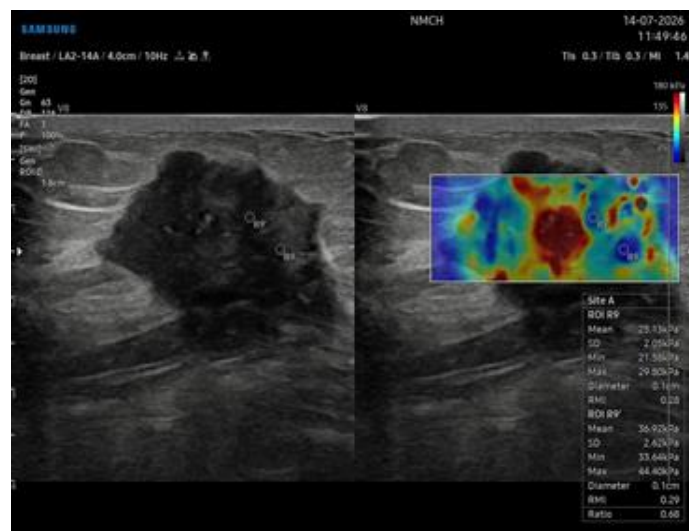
B-mode ultrasonography (left) and shear-wave elastography (right) demonstrating an irregular hypoechoic left breast mass with markedly increased tissue stiffness, consistent with a highly suspicious malignant lesion (BI-RADS 5).
